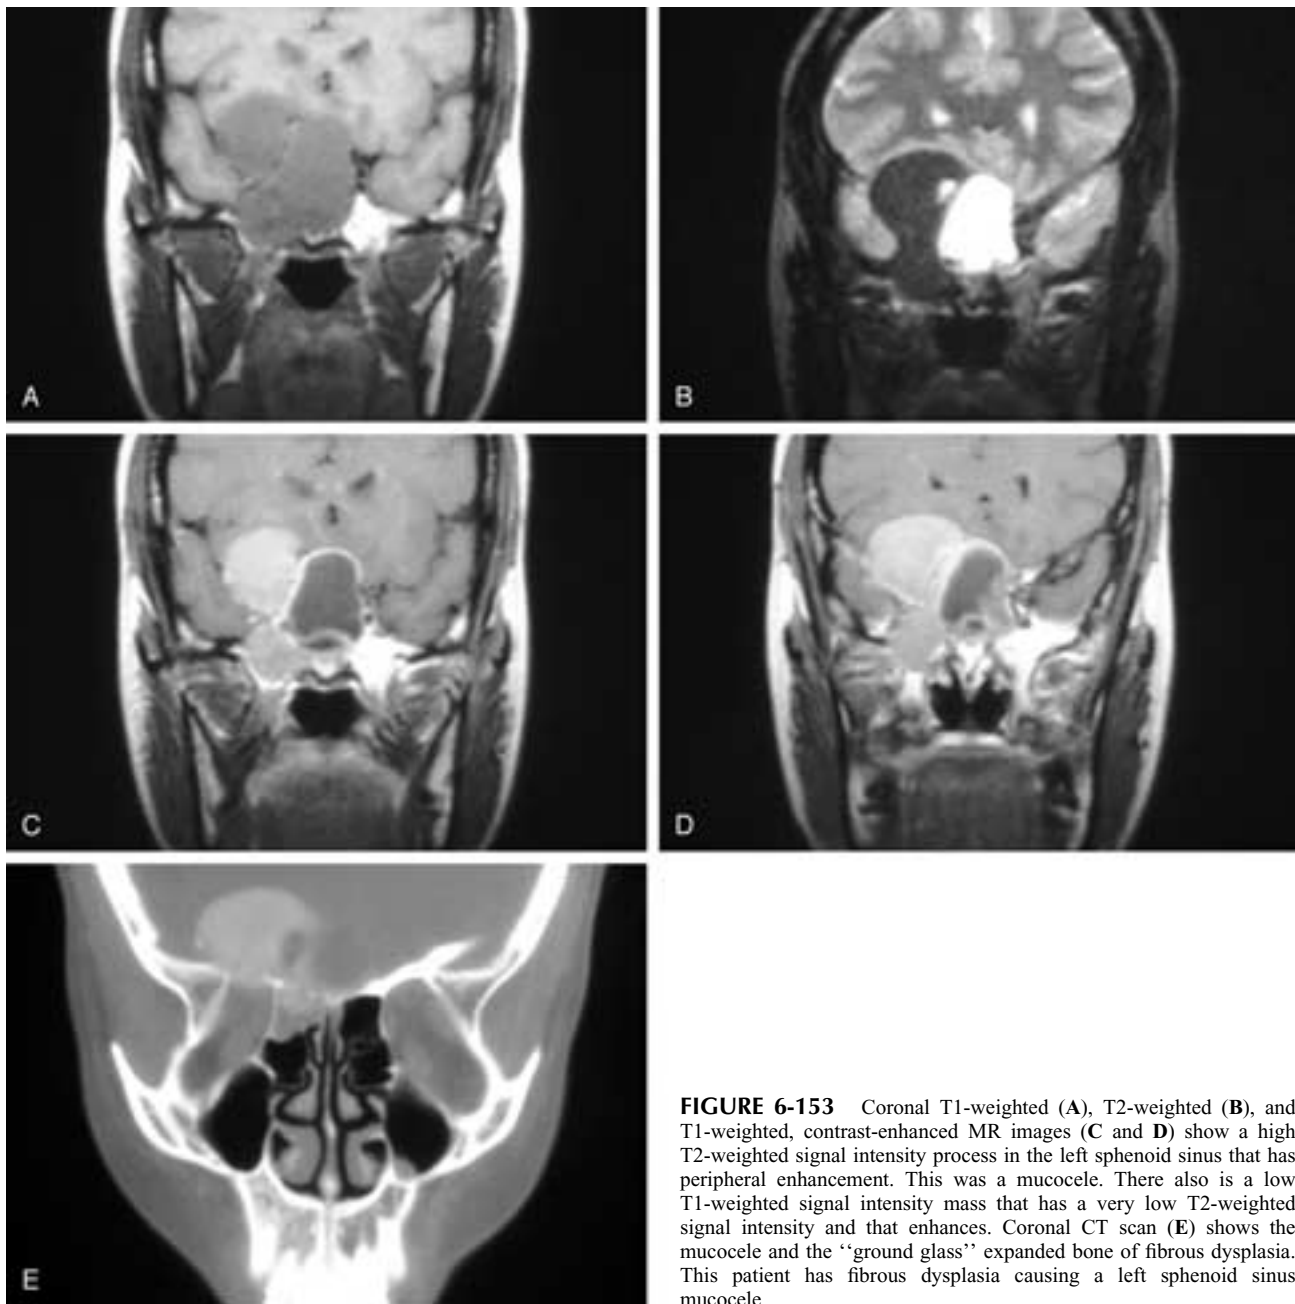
Coronal T1-weighted (A), T2-weighted (B), and T1-weighted, contrast-enhanced MR images (C and D) show a high T2-weighted signal intensity process in the left sphenoid sinus that has peripheral enhancement. This was a mucocoele. There also is a low T1-weighted signal intensity mass that has a very low T2-weighted signal intensity and that enhances. Coronal CT scan (E) shows the mucocoele and the “ground glass” expanded bone of fibrous dysplasia. This patient has fibrous dysplasia causing a left sphenoid sinus mucocoele.
